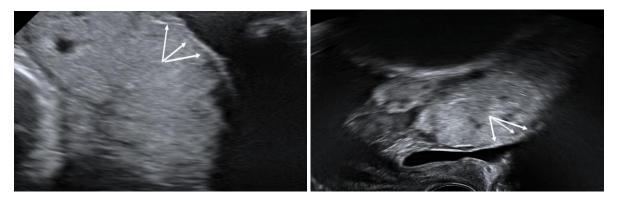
Myometrium less than 1 mm. – transabdominal ultrasound examination
